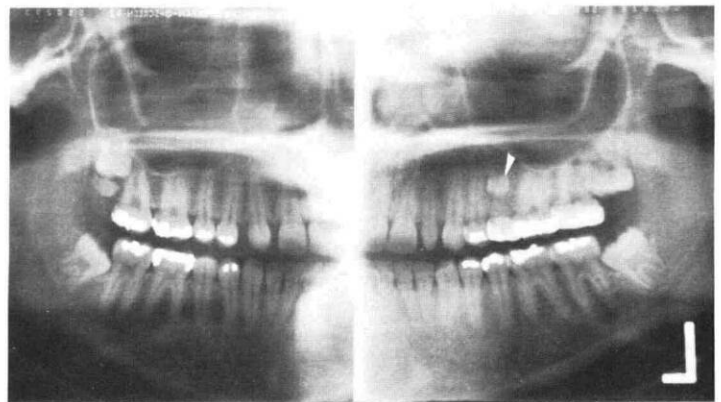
Panoramic radiograph at 17 years, 1 month.
